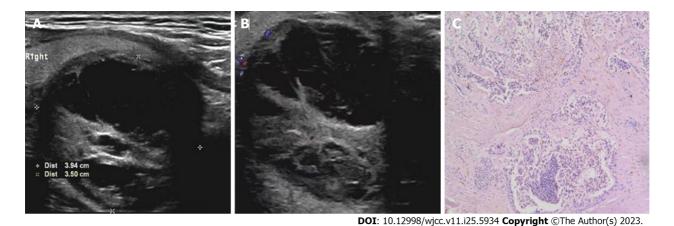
Parathyroid carcinoma of the lower pole of the thyroid on the right side in a 59-year-old man. A: Doppler ultrasound revealed a complex nodule (with mixed echogenicity), i.e., with solid and fluid components; B: Color doppler flow imaging indicated punctate blood flow signals were detected in the solid part of the nodule and its periphery; C: The neoplastic chief cells of the parathyroid glands were arranged in solid sheets, nests and acini, indicating diffuse infiltrative growth.
